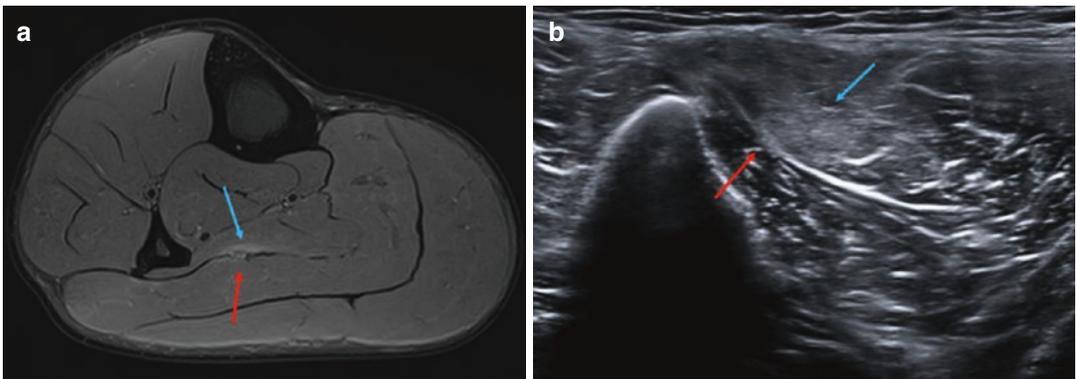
Image of a soleus lateral aponeurosis rupture. (a) Axial T2 FS MRI image showing a subacute rupture of the lateral aponeurosis of the soleus muscle (red arrow) with surrounding edema (blue arrow). (b) Transversal ultrasound view of the same injury. The rupture (red
